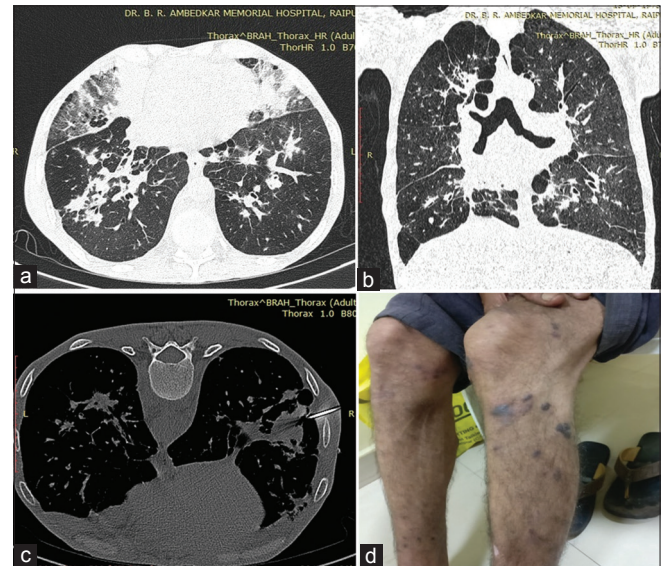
(a) Axial HRCT image and (b) coronal reformatted images showing thickening of peribronchovascular bundles with characteristic flame-shaped nodules in peribronchovascular distribution. Consolidation with ground-glass opacity and reticular opacities noted in the bilateral middle lobe. (c) Image showing computed tomography-guided biopsy from the lesion. Biopsy demonstrated Kaposi sarcoma. (d). Clinical image showing vascular skin lesions.
